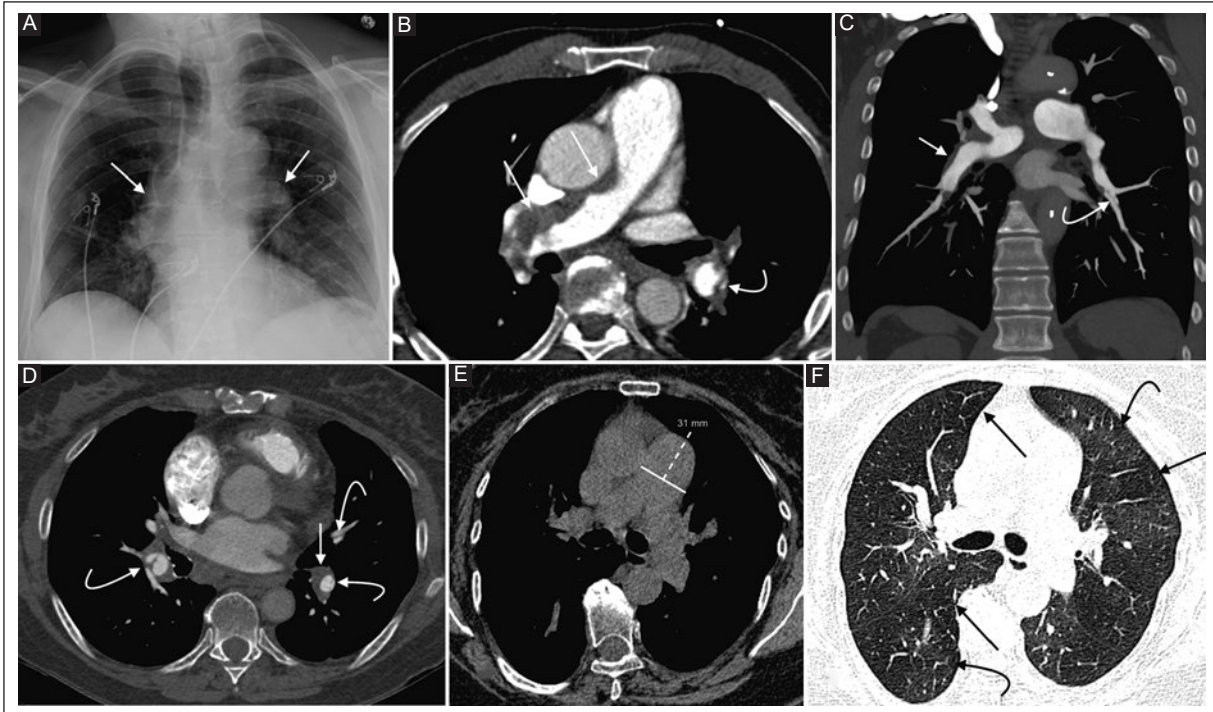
A 77-year-old male patient. A: portable chest radiograph, anteroposterior view. Prominence of the pulmonary artery (arrow) and its branches as signs of pulmonary arterial hypertension. B: CTPA, axial image, and C: coronal reconstruction in maximum intensity projection. Dilatation of the main pulmonary artery due to pulmonary arterial hypertension. Filling defect towards the wall of the right pulmonary artery with smooth contours and forming an obtuse angle with the vessel wall (arrow). There are some bands inside the artery of the left lower lobe; both findings are related to chronic pulmonary embolism (curved arrow). D: a 66-year-old female patient. CTPA, axial image. Partial filling defect in the lumen of the pulmonary artery of the right lower lobe and other thinner ones in segmental branches of the lower lobes related to chronic pulmonary embolism (curved arrow). There is also thickening of the pulmonary artery wall of the left lower lobe (arrow). E: a 59-year-old female patient with episodes of recurrent pulmonary embolism. Non-enhanced chest CT, axial section in the mediastinal window showing dilatation of the main pulmonary artery due to pulmonary arterial hypertension. F: non-enhanced chest CT, axial image in the lung window. There are geographically arranged “ground glass” areas, with areas of hyperemia (increased attenuation) (curved arrow) and oligemia (less attenuation) (arrow). Findings related to CTEPH.
